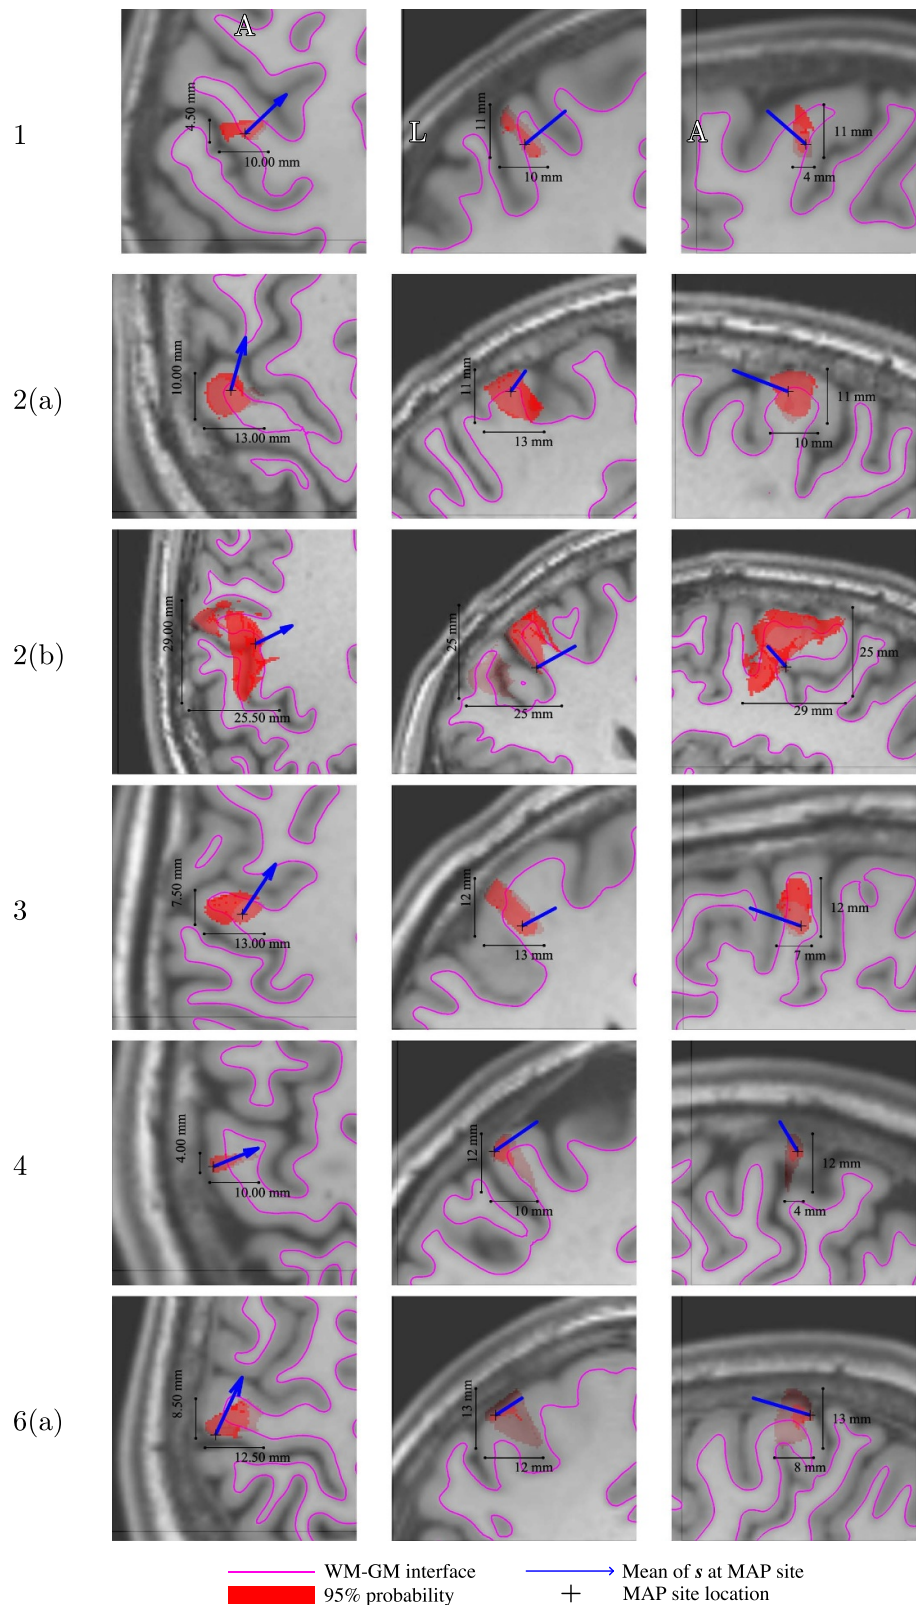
The 95% probability volume parallel-projected over T1-weighted MR-images of axial, coronal and sagittal slices (left to right) intersecting r_{MAP} . Anterior and left direction symbols are overlaid over the first set of images. Note that the MRI slice is rendered in transparent making the part of 95% volume beneath the slice visible.
